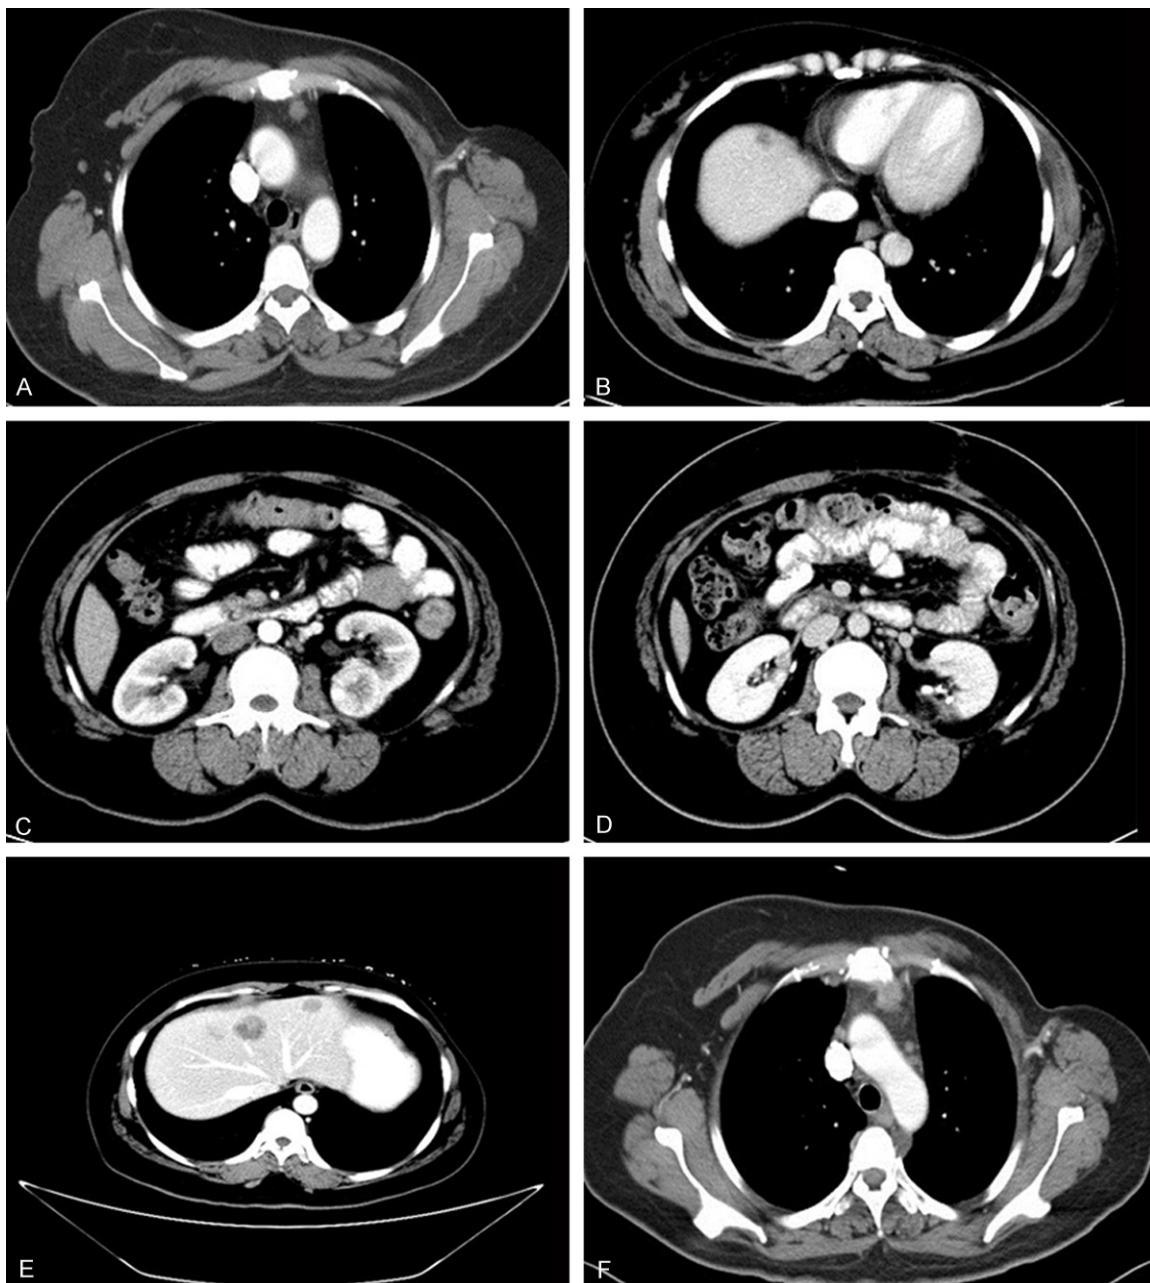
A. Chest CT: mediastinal lymph node enlargement, consider for breast cancer metastasis. B. Abdomen CT: intrahepatic nodules, consider for metastatic carcinoma. C. CT scan with the left renal mass, 3.0 cm in diameter. D. Abdomen CT after RCC operation. E. Metastatic disease progressed in the liver (4 months after RCC operation). F. Mediastinal metastatic disease progressed (4 months after RCC operation).
